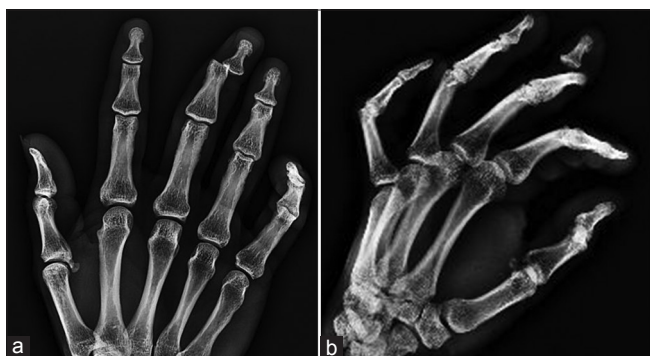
(a and b) X-ray views showing dorsoulnar distal interphalangeal joint dislocation with increased joint space
